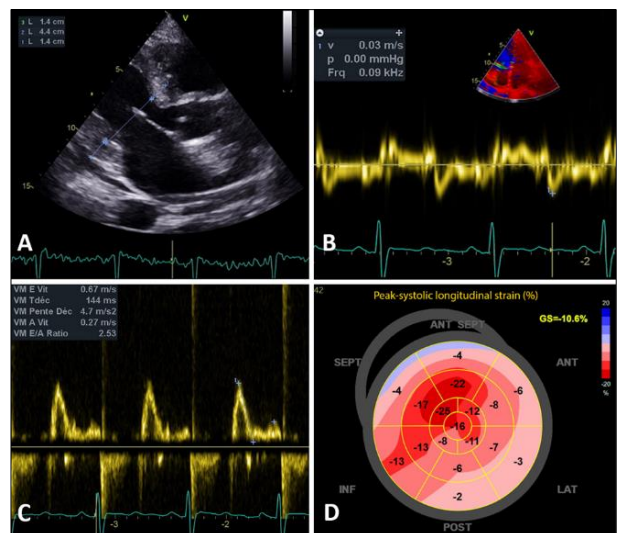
Transthoracic echocardiography findings. Panel A: Parasternal long axis view showing LV concentric hypertrophy. Panel B: severely impaired e' at the septal mitral annulus during tissue doppler imaging. Panel C: Restrictive mitral inflow pattern. Panel D: Altered global peak longitudinal strain with an apical sparing-pattern
